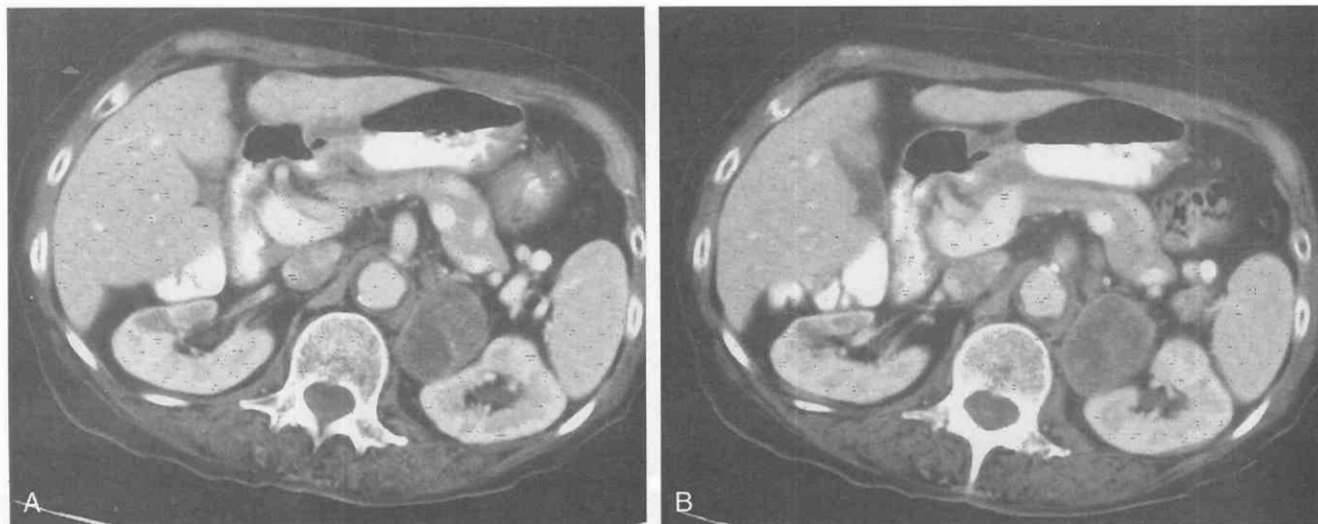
Adrenal metastasis. A and B, Contrast-enhanced CT scans of the abdomen reveal a 4.5-cm left adrenal mass that is inhomogeneous and irregular. The patient had an underlying lung carcinoma; percutaneous biopsy indicated left adrenal metastasis.
